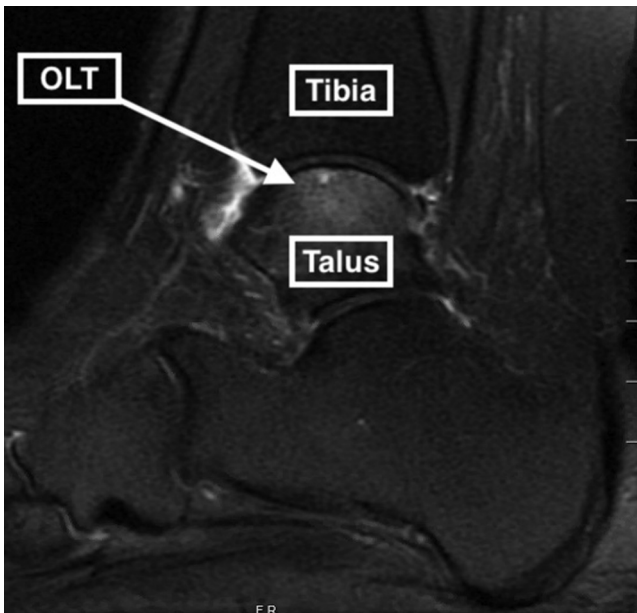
Sagittal magnetic resonance imaging scan view of left ankle showing osteochondral lesion of lateral talus (OLT).
